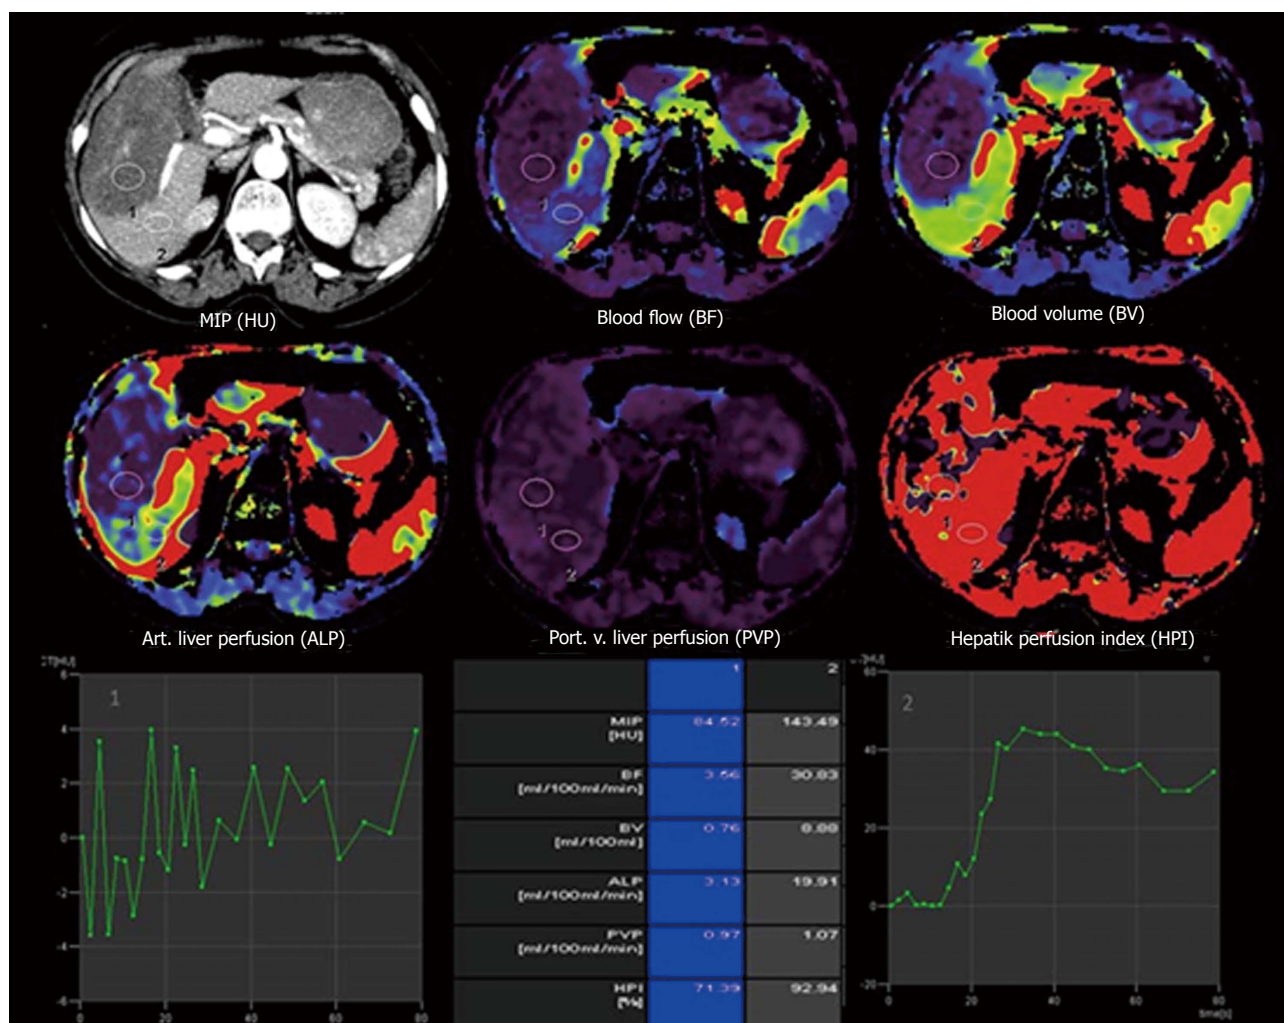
Transverse computed tomography perfusion functional maps of the blood volume, blood flow, portal-venous perfusion, arterial liver perfusion and hepatic perfusion index in a 49-year-old woman show a large alveolar echinococcosis lesion in the right lobe of the liver that has a distinct range of colors compared with the background liver parenchyma. Perfusion values from an ROI drawn in the solid component without calcification of alveolar echinococcosis (ROI 1) and normal tissue (ROI 2) show lower blood flow, blood volume, arterial liver perfusion and portal-venous perfusion values compared with normal liver parenchyma.
